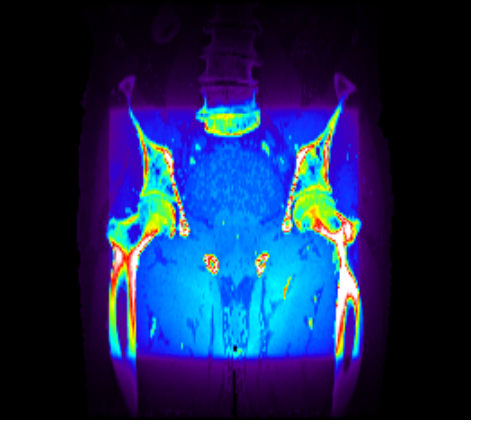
Isocentric slices for Pat. E for a single beam at 0° . The slice positions are marked in the CT-slices shown in (n) - (p).
